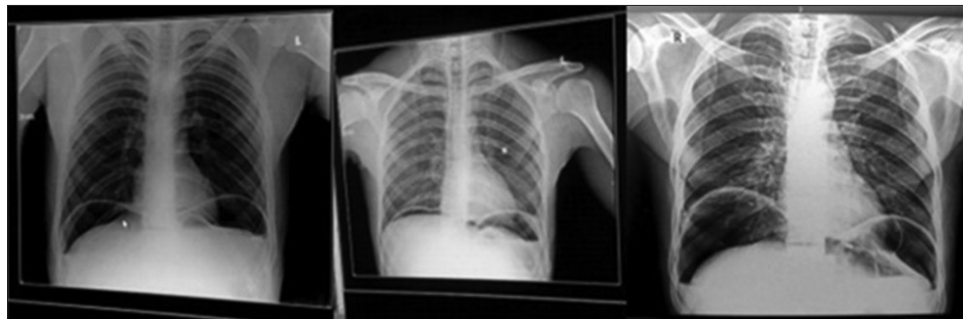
Plain chest radiographs showing air under diaphragm.
